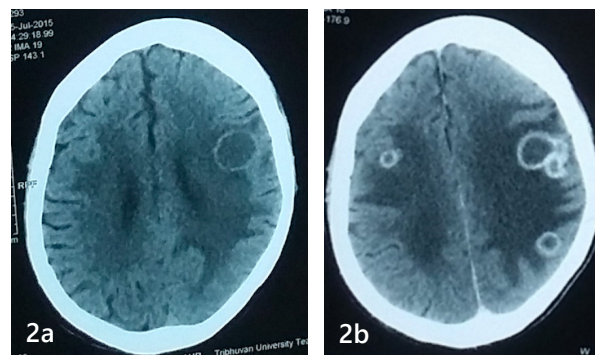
Non-contrast computed tomography (CT) scans of head at the level of body of lateral ventricles and supraventricular level showing hypodense round lesion with a thin isodense peripheral wall in left frontal lobe. Figure 2b. Contrast CT image showing peripheral wall enhancement of left frontal lobe lesion. Multiple other ring enhancing lesions are also seen in bilateral frontal lobes and left parietal lobe. Marked surrounding hypodensity is seen suggestive of perilesional edema.
